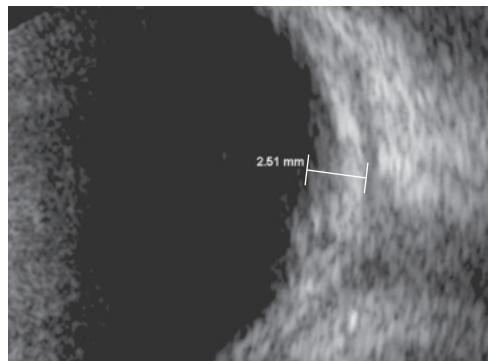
B-scan ultrasound image from a patient with posterior scleritis showing localized posterior scleral thickening (—). (Courtesy of James J. Reidy, MD.)
